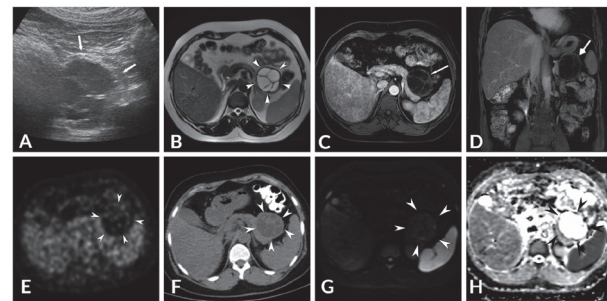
The transabdominal ultrasonography shows a multiseptated cystic structure on pancreatic body and tail (arrows) (A). Axial T2- weighted MRI scan demonstrates “spoke wheel” appearance of hydatid cyst (arrowheads) (B). After intravenous contrast medium administration, mild enhancement of the walls and septa is seen on both axial and coronal T1-weighted MRI (arrow) (C, D). Axial PET CT scans depict non 18F-FDG avid pancreatic cystic lesion (arrowheads) (E,F). There is no significant diffusion restriction detected on diffusion-weighted MRI and ADC map (arrowheads) (G, H).
